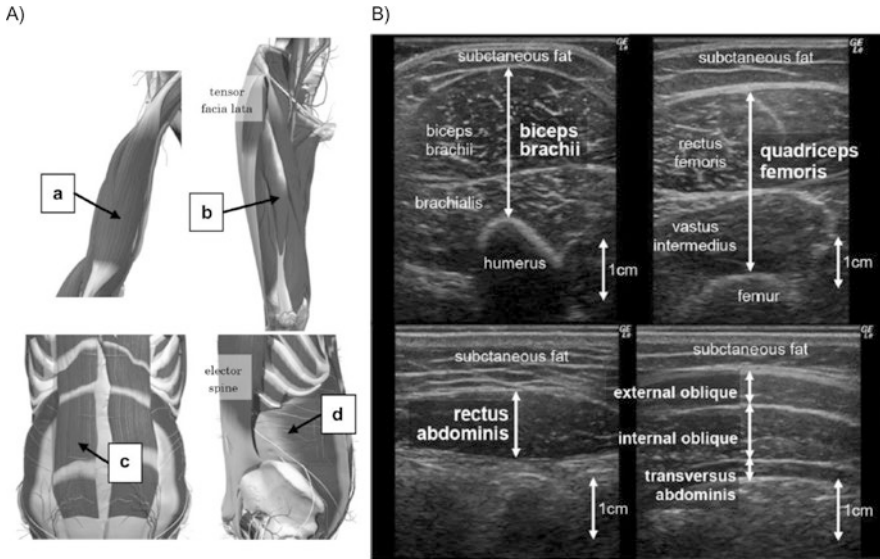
(a) Ultrasound sites for each muscle. *a.* Biceps brachii, two-thirds of the way between the acromion and the antecubital crease. *b.* Quadriceps femoris, midway between the anterior superior iliac spine and the proximal end of the patella. *c.* Rectus abdominis, 3 cm lateral to the umbilicus. *d.* External oblique, internal oblique, and transversus abdominis, 2.5 cm anterior to the midaxillary line, at the midpoint between the inferior rib and the iliac crest. (b) Representative ultrasound images. Echo intensity (EI) can be assessed by computer-assisted 8-bit gray-scale analysis using the standard histogram function in Adobe Photoshop Elements (Adobe Systems, San Jose, CA, USA) or other image software as an index of muscle quality. (The figure is reprinted from Fukumoto et al. 2015 [52] with permission)
